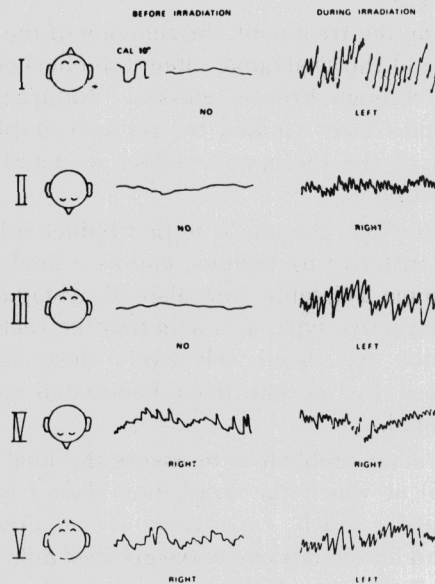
Nystagmography curves from a patient during ultrasonic irradiation.
